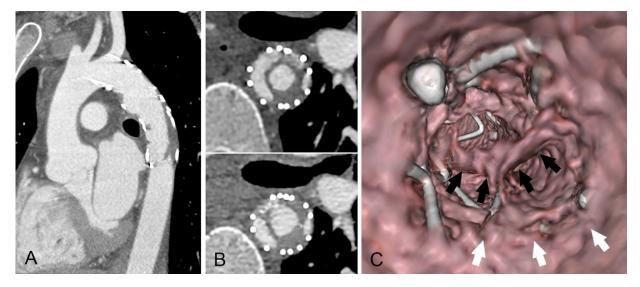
A, Twenty-four-month computed tomography angiography (CTA) showing mural thrombosis within the middle-distal portion of the stent graft. B, At 30 months, the amount of intragraft thrombus is increased, with appearance of endoluminal septa. C, Virtual angioscopy of the intragraft lumen confirming the presence of mural thrombus (white arrows) and intraluminal septa (black arrows).
